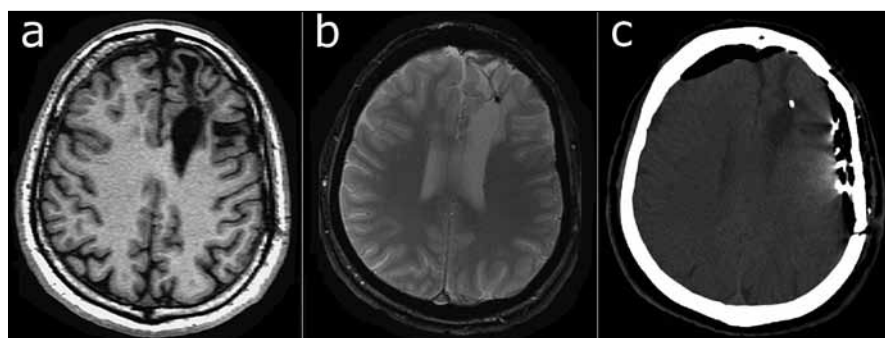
T1-weighted MP-RAGE sequence. A large post-surgical defect may be seen in the left frontal region.
